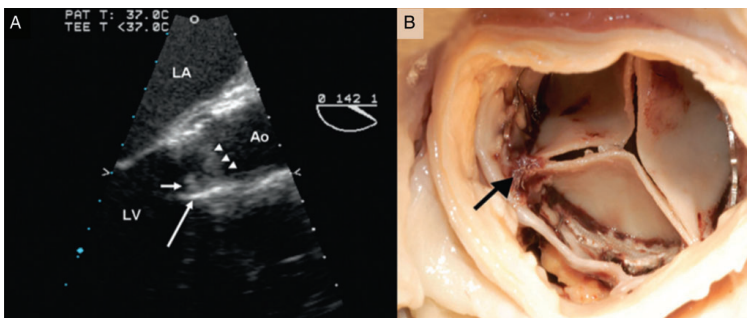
Transcatheter heart valve thrombosis. (A) Transesophageal echocardiogram of a case of transcatheter heart valve thrombosis demonstrating the valve stent (long white arrow), thrombus on the stent (short white arrow), and thickened valve leaflets. (B) Post-mortem image of thrombi on the outflow of the stent frame (black arrow). Reprinted with permission from Tay.⁹⁸
